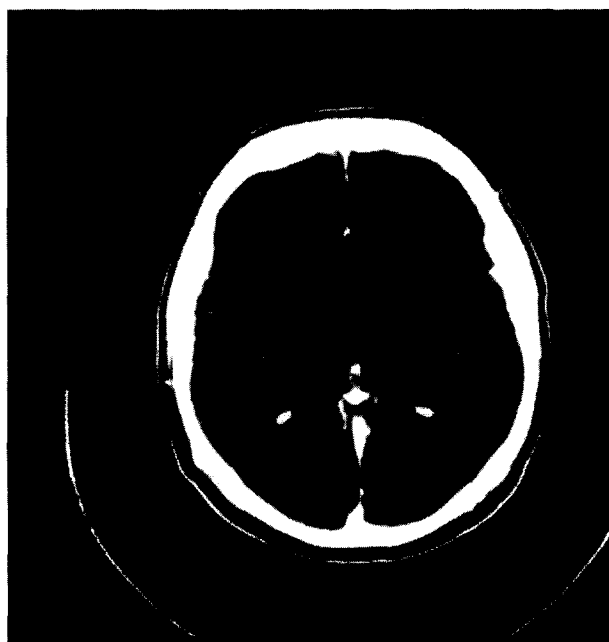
(a) Computer tomography (CT) with contrast of the brain showing multiple supratentorial enhancing lesions with oedema. (b) CT scan 6 months later, showing the complete resolution of the brain metastases with tamoxifen treatment.
